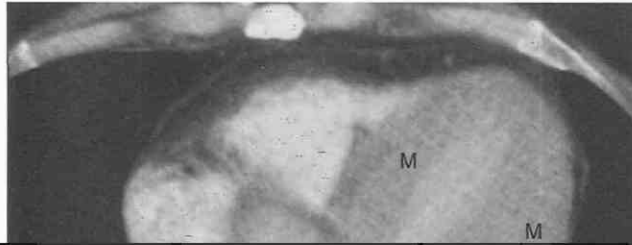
Left ventricular hypertrophy in a patient with systemic hypertension, aortic stenosis, and aortic regurgitation. Axial contrast-enhanced CT image shows the markedly thickened left ventricular myocardium (M). The aortic valve is not calcified.
